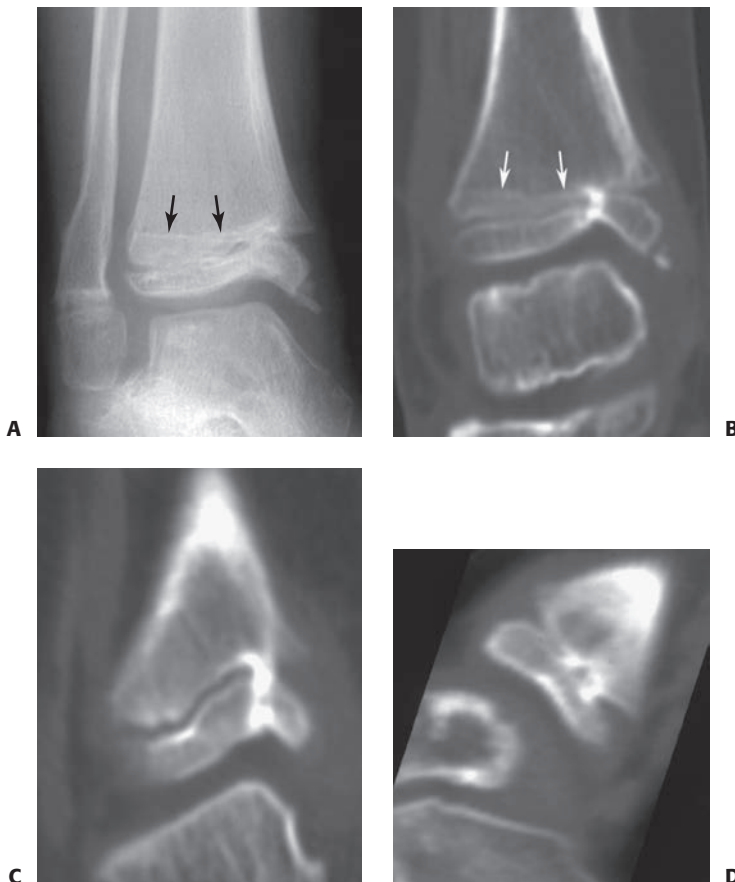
Harris growth arrest line tapering to the physis at the level of the growth arrest can serve as an excellent radiograph confirmation of the presence of the true growth arrest. Although most commonly noted on plain radiographs, these arrest lines can be seen on CT scans and MRIs as well. A: Anteroposterior radiograph of the distal tibia after Salter–Harris type IV fracture demonstrates a Harris growth arrest line (*arrows*) tapering to the medial distal tibial physis, where a partial physeal arrest has formed. B: Harris growth arrest line (*arrows*) as noted on CT. CT scans with coronal (C) and sagittal (D) reconstructions corrected for bone distortion provide excellent images of the location and size of arrest.
